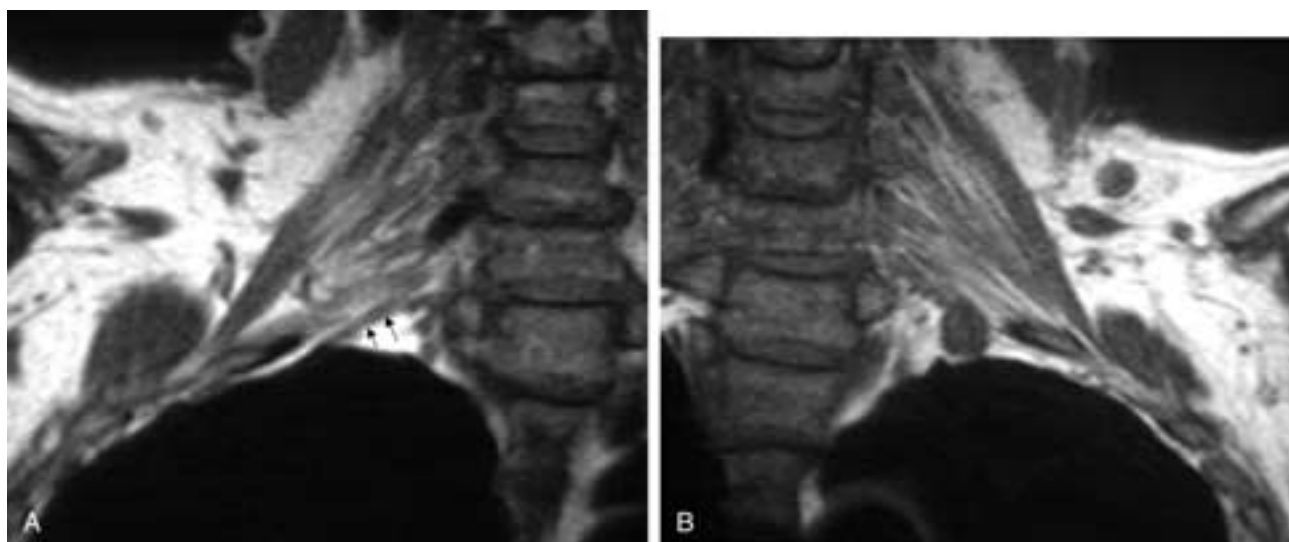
Status after a stab wound to the root of the neck with increasing arm pain. T1-weighted MR coronal image (A) shows a normal inferior trunk of the right brachial plexus (*arrows*). Image B demonstrates a well-circumscribed intermediate signal intensity lesion inseparable from the inferior trunk of the brachial plexus on the left. This is consistent with a posttraumatic neuroma.
